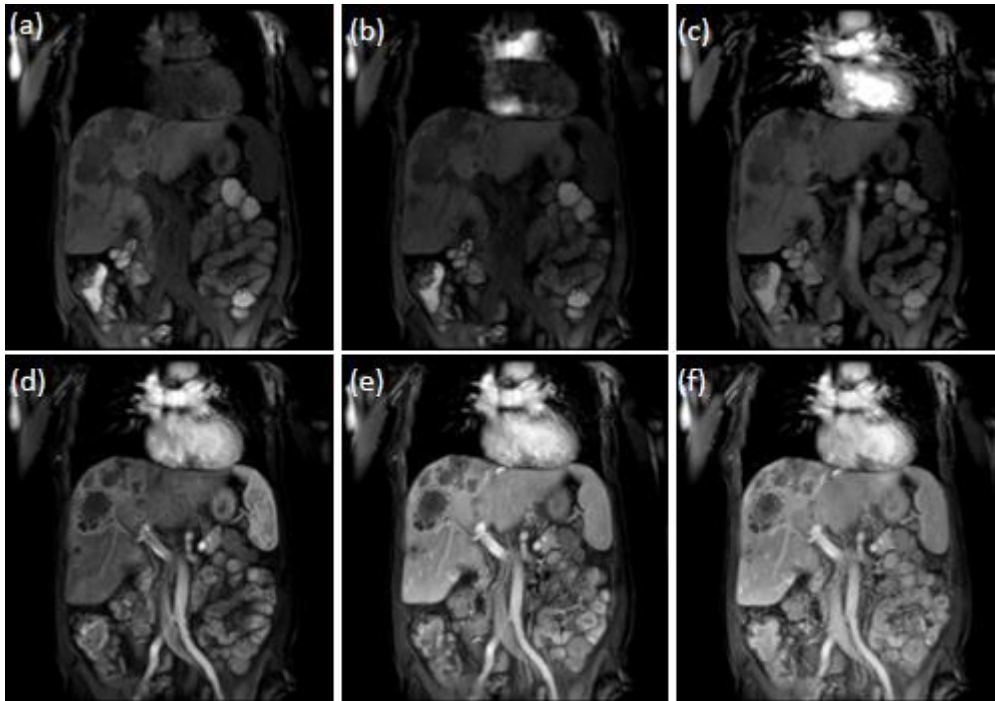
Examples of DCE-MRI data of a patient with liver cancer, acquired in the coronal plane. (a) pre-contrast frame, (b) (c) (d) bolus arrival and contrast agent uptake, (e) (f) post contrast washout phase.
